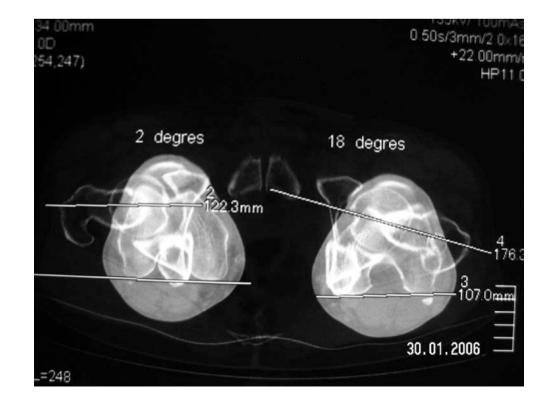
In case of rotational deformity, a CT-Scan is required to measure the femoral neck anteversion/retroversion according to the posterior condyles line
